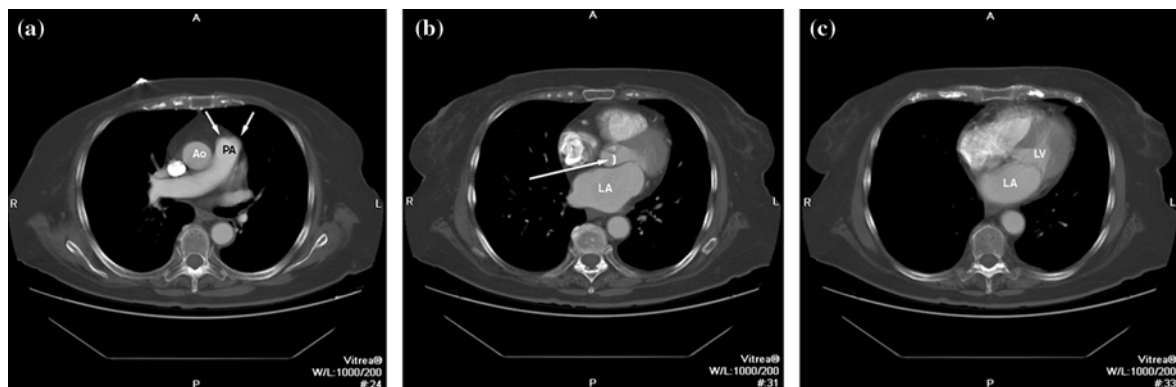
Axial images obtained from an ungated contrast-enhanced multidetector CT examination from an 83 year old woman with aortic stenosis. (a) Section through the sinuses of Valsalva of the main pulmonary artery (arrows). At this level, the ascending aorta (Ao) is greater in caliber than the main pulmonary artery (PA). (b) Section through the aortic valve and left atrium (LA). The calcified aortic valve leaflet (arrow) is identified as a curvilinear high attenuation within the aortic annulus. (c) Section through the LA and left ventricle (LV). The left ventricular myocardium is thickened. The heart is not enlarged.
